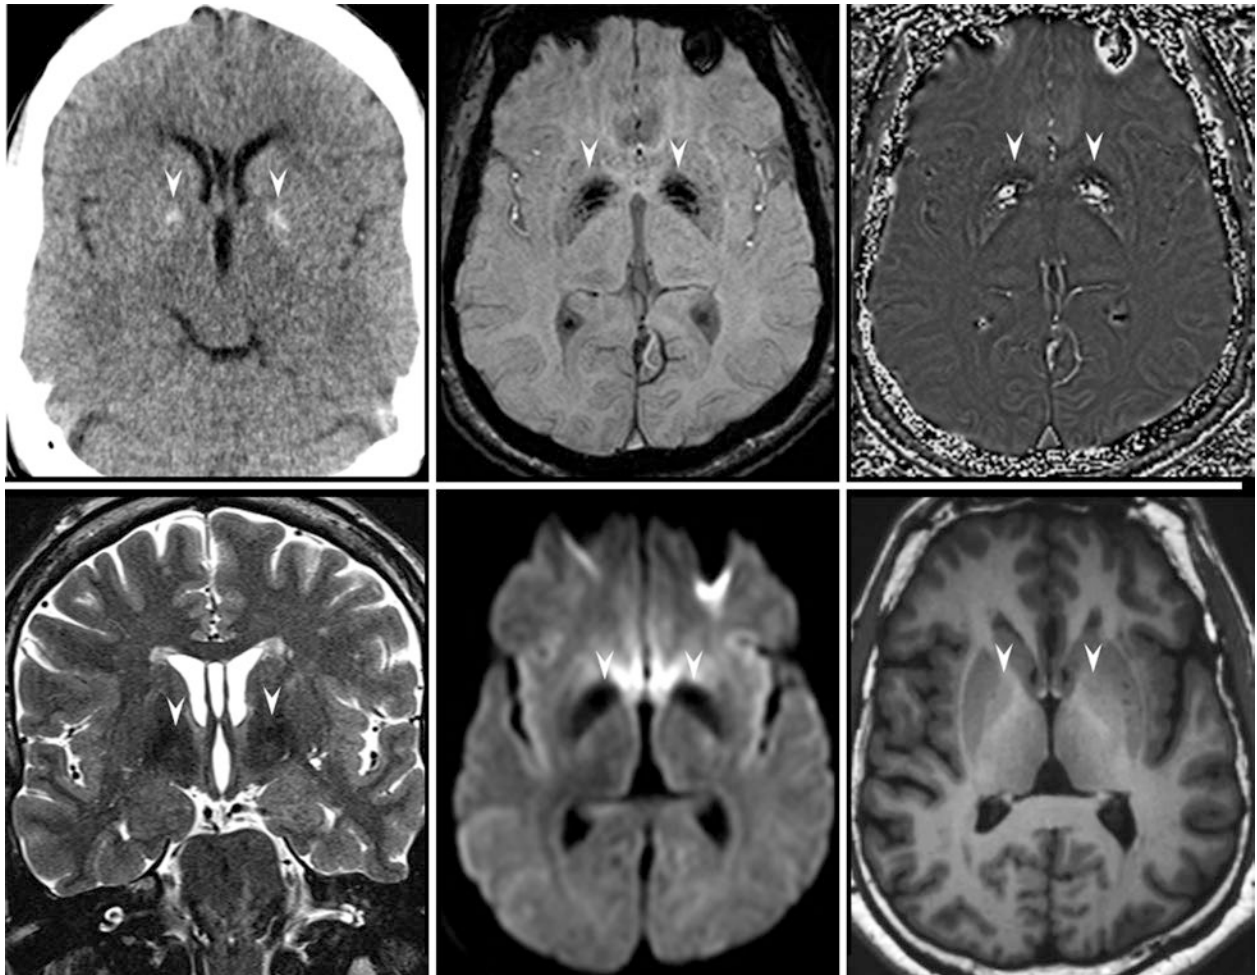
In a 51 year old pallidal calcium (*arrowheads*) on a NECT (*top left*) are, on a left-handed 3T MRI, located within larger areas of dark signal on SWI (*top middle*) that are bright on phase maps (*top right*) and dark on T2WI (*bottom left*) and DWI (*bottom middle*). The
